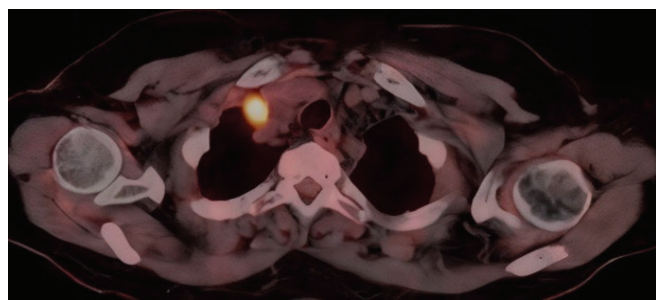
PET-CT of a supraclavicular lymph node (SUVmax 28.7) showing necrotizing granulomatous inflammation, initially misdiagnosed as malignant.
